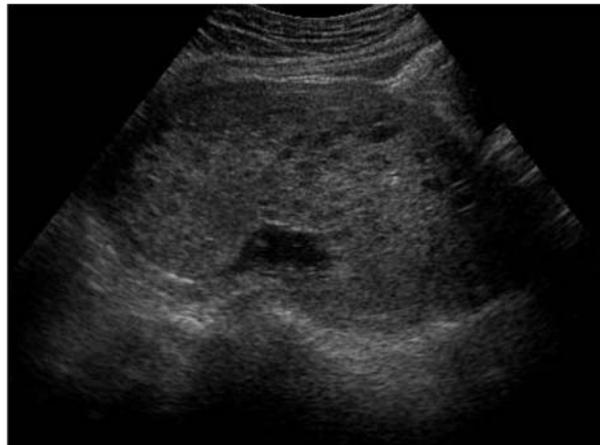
Complete mole on ultrasonography.
